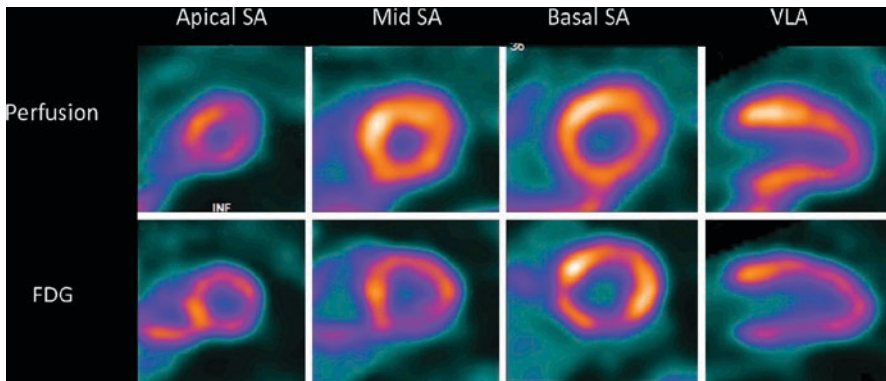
PET perfusion with N13-ammonia (top row) and FDG (bottom row). Left 3 columns: short-axis view, right column: vertical long-axis view. Diffuse (physiologic) FDG uptake is observed, secondary to suboptimal patient preparation
